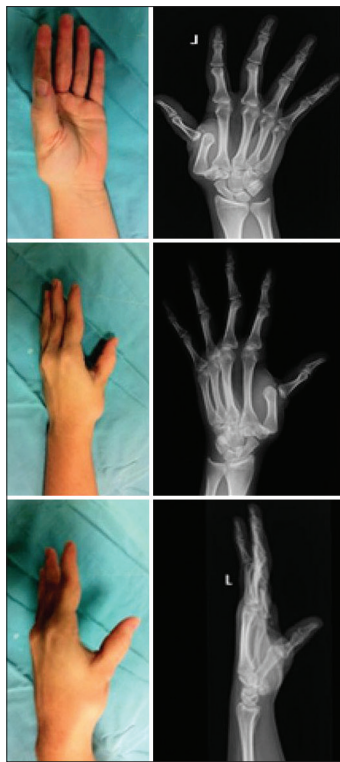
Prereduction pictures and radiographs of the left hand
